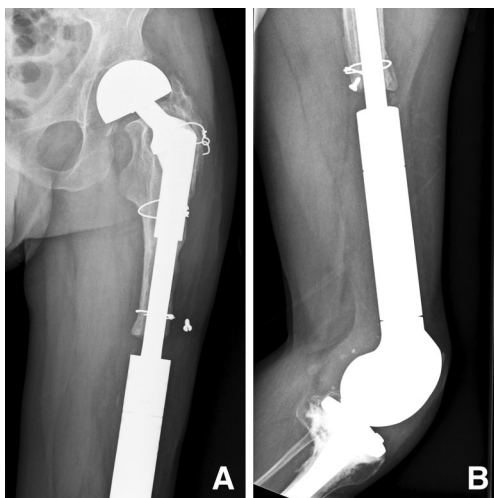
An example of the push-through prosthesis taken five years postoperatively. a Anterior-posterior radiograph of the left hip and proximal femur. Note how the proximal muscle attachments are spared. Extra cerclage wires are used to improve post-operative fixation of the remaining bone. The Link Variocup is used in this case (hemiarthroplasty). b Lateral radiograph of the rotating-hinge construction of the PTF. The distal femur has been replaced with a modular push-through construction
